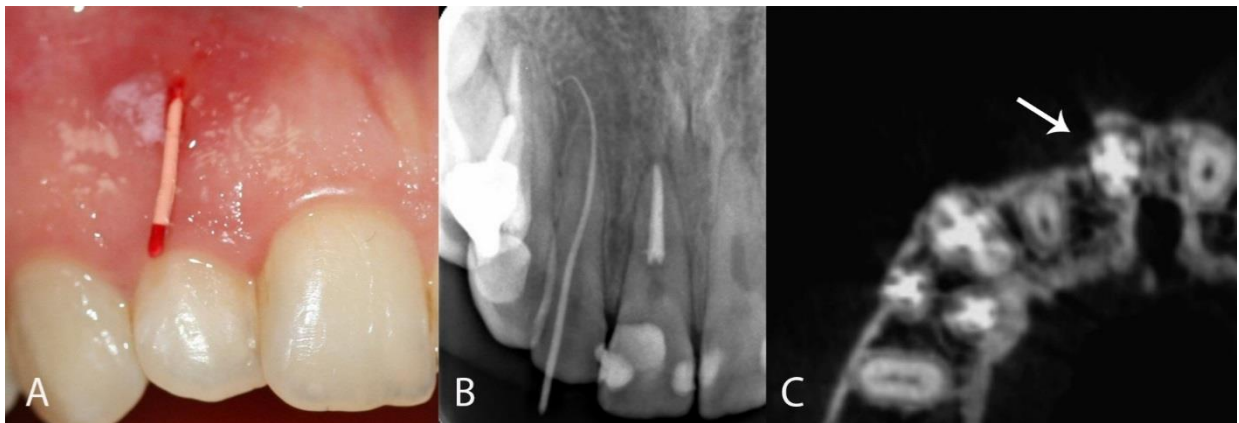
A) Tracing the sinus tract; B) Gutta-percha stopped between tooth # 7 and #6; C) Axial view of the CBCT: a radiolucent area was detected around the distal part of tooth #8 at the level of the previously detected lateral canal
